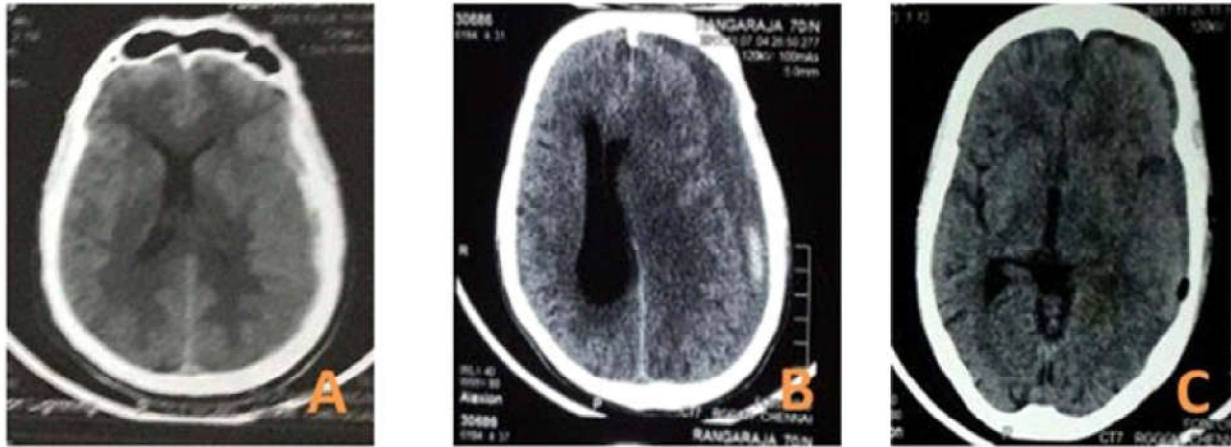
Case 2. CT scans of 70 year old male with history of RTA. A: on admission. B: on day 15. C: post burrhole evacuation.
